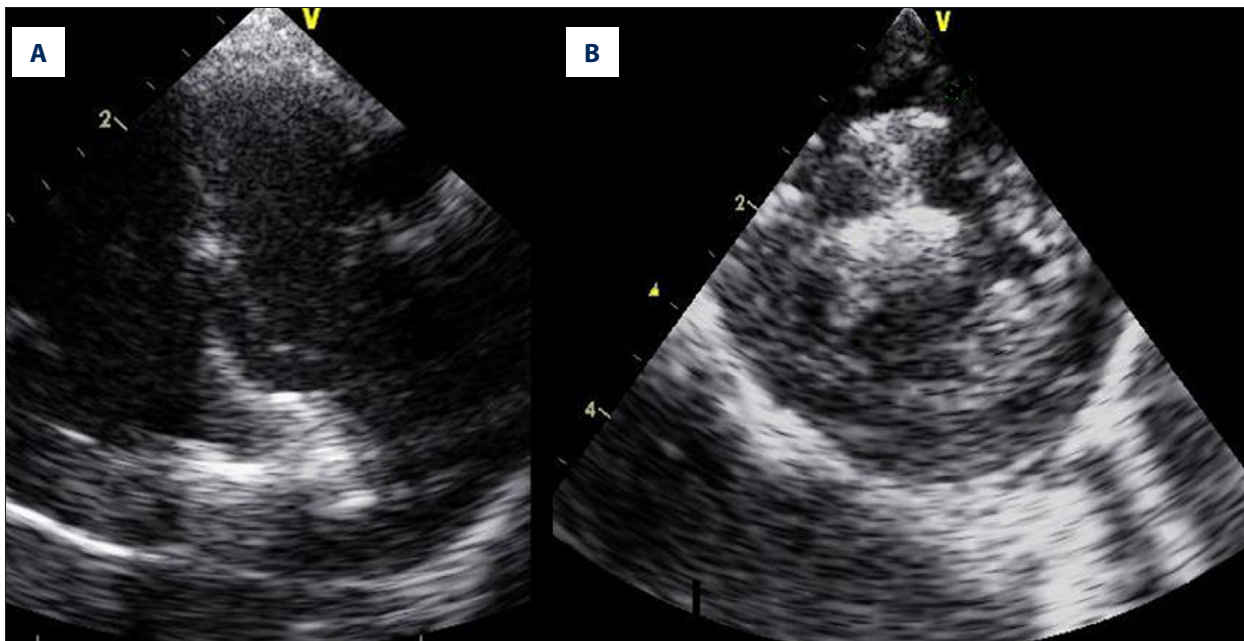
The muscular ventricular septal defect occluding device implanted into the septum – transoesophageal echocardiography image (TEE) (A) and epicardial echocardiography (EE) image (B).
